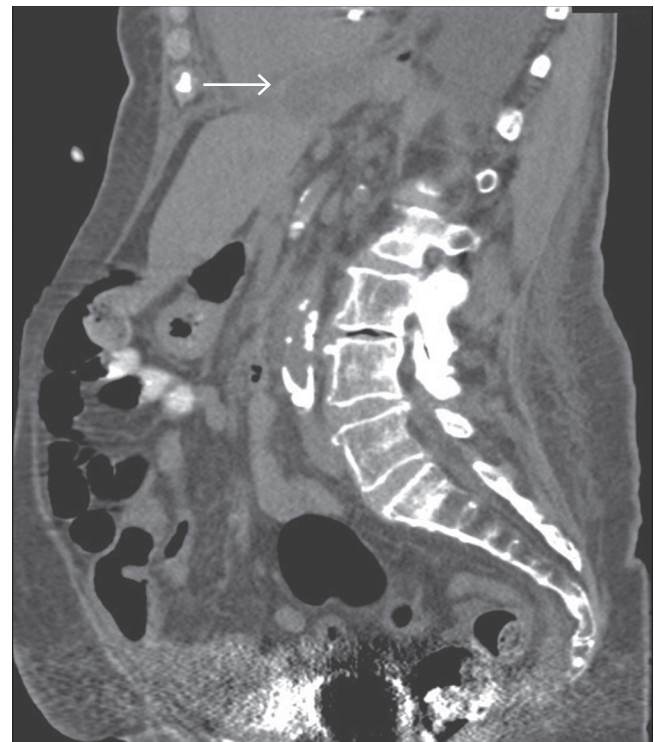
Sagittal abdominal CT showing interval improvement in collection (arrow).
